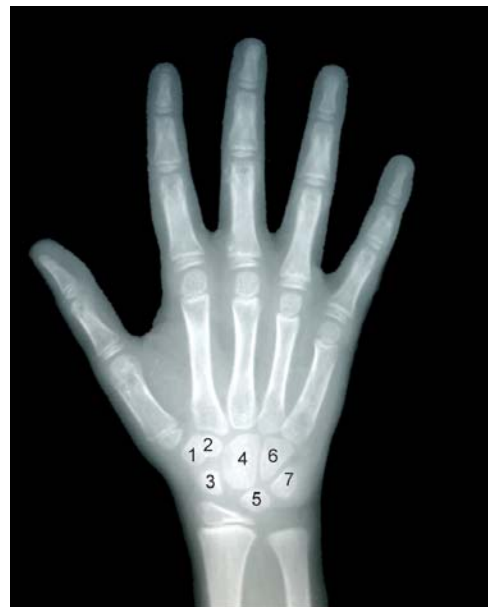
Hand wrist radiograph of a 8 year-old-child. Note the missing pisiform bone as it begins to calcify at 12 years of age
